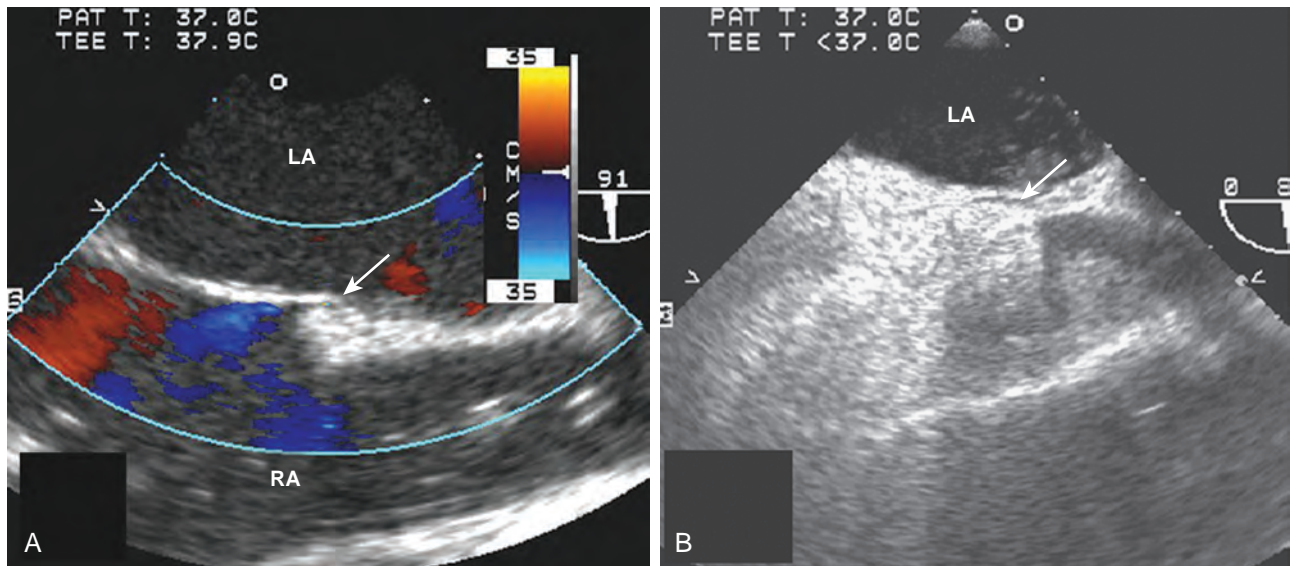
Detection of a patent foramen ovale (PFO) in a patient undergoing cardiac surgery. A 68-year-old patient was undergoing two-vessel off-pump coronary artery bypass grafting. In addition to coronary artery disease, the patient had a medical history of hypertension, non-insulin-dependent diabetes, and a stroke of unknown cause. (A) The intraoperative transesophageal echocardiographic examination that included an inspection of the interatrial septum in the midesophageal four-chamber, and bicaval imaging planes showed a new finding of an aneurysmal interatrial septum with a PFO (arrows). Color-flow Doppler showed minimal shunt flow from the left atrium (LA) to the right atrium (RA). (B) The presence of the PFO (arrow), which was initially diagnosed by color-flow Doppler imaging (A), was confirmed by the transient flow of injected contrast (arrow) into the LA after it was injected into the venous circulation. A provocative maneuver such as Valsalva transiently increases pressure of the RA more than that of the LA, thus increasing the sensitivity of PFO detection.⁴⁷ Because of the patient's history of a cryptogenic stroke, the surgical plan and circulatory management were altered. The patient was fully heparinized and circulation was supported by an extracorporeal pump while the coronary artery bypass graft was performed and the PFO was closed.
